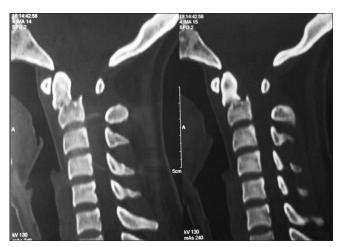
CT showing type II odontoid fracture
